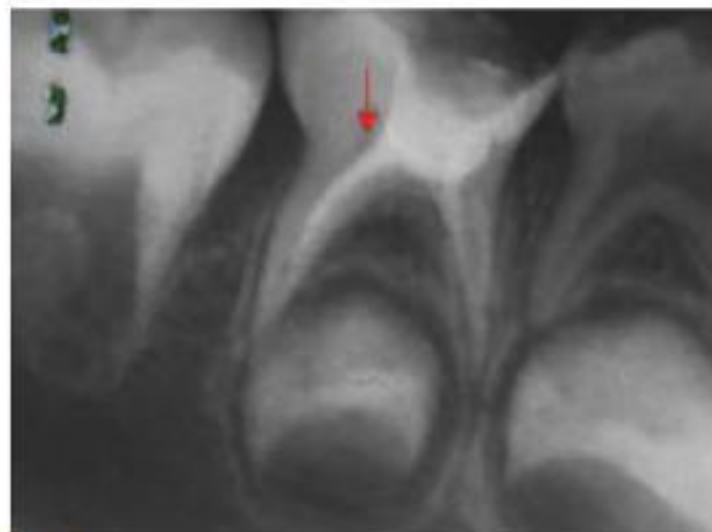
IOPA- X-ray of endodontically treated primary tooth (arrow shows Dycal Obturation)
